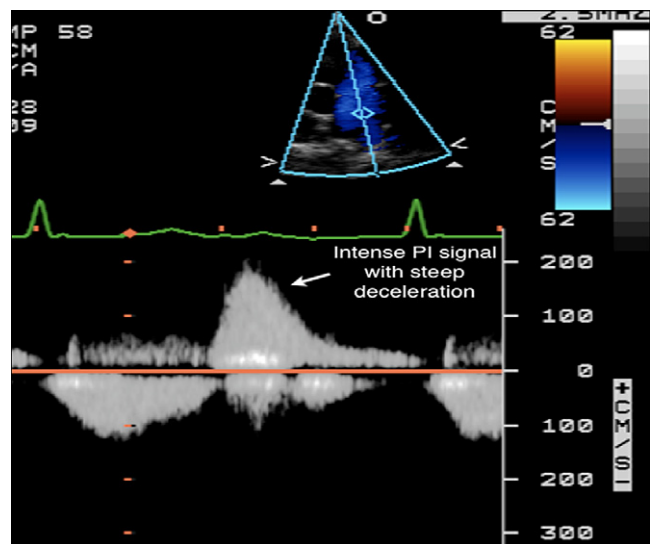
Continuous-wave Doppler through the pulmonic valve shows steep deceleration and intense signal of PI jet on transthoracic echocardiography.
